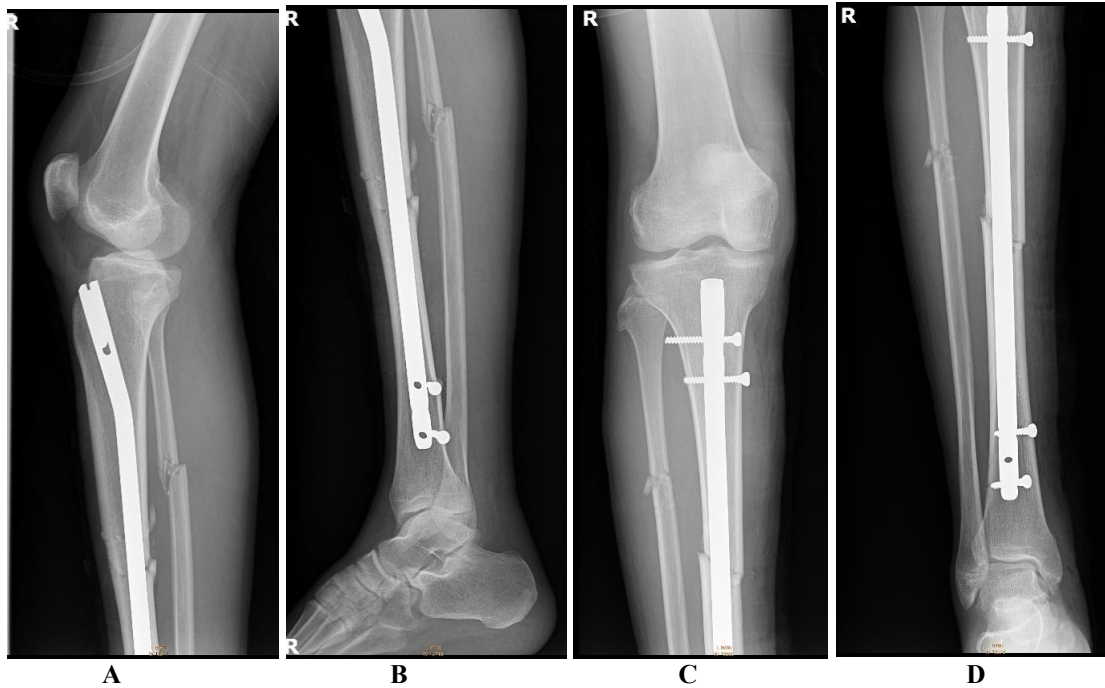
(A) (C) Anterior posterior and (B) (D) lateral X-ray views of the Tibia/Fibula exposing the knee joint, showing complete cortical edging of both fractures
